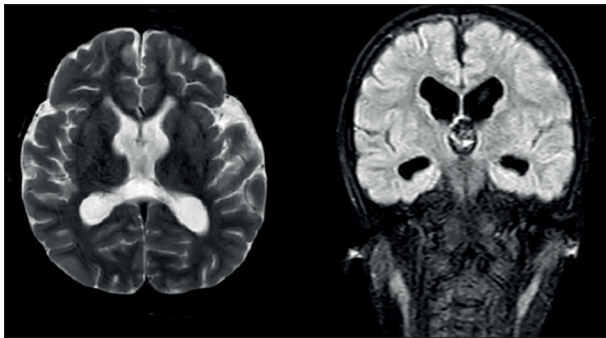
Axial T2 and Coronal T2 FLAIR Cranial MRI images of the patient showed a thin corpus callosum, ventriculomegaly, and white matter atrophy.
